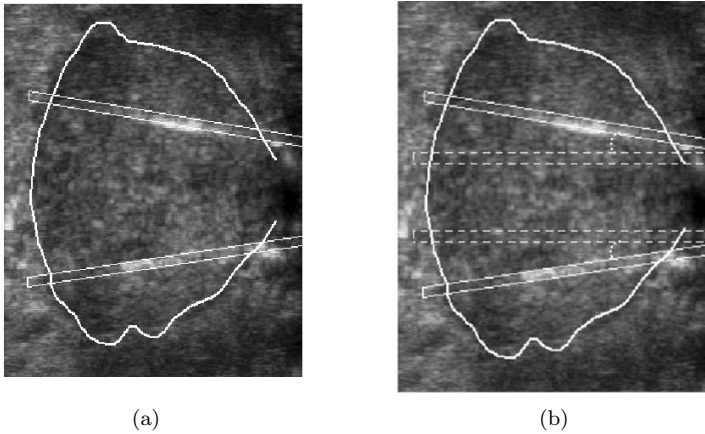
Example of (a) an ultrasound scan with the seed trajectories and (b) how the angles are calculated. The dashed lines depict the needles, the solid lines are the seed trajectories, and the dotted lines indicate the angle between those two.
